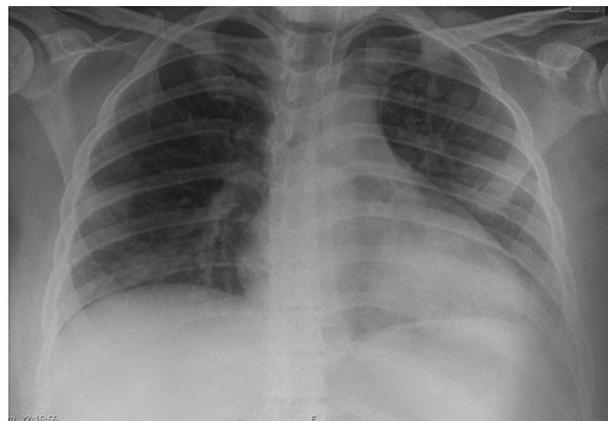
Chest X-ray of patient 2 showing lower lobe patchy consolidation consistent with (COVID) pneumonia.
